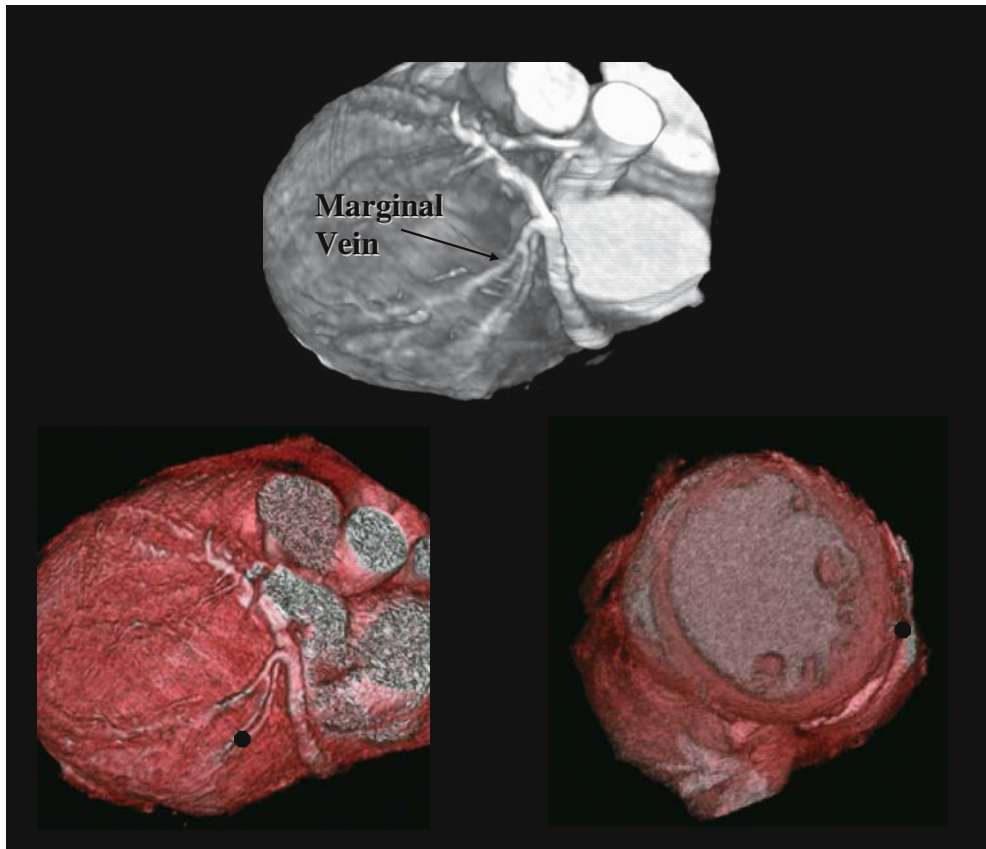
CT coronary angiogram demonstrating the coronary venous system (top panel). Three-dimensional localization of the myocardial segment associated with a particular segment of the marginal vein is displayed (black circle, lower panels).
